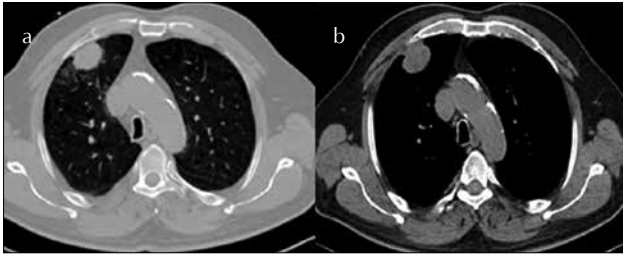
a, b. Computed tomography image: A 4-cm lesion in the right upper lobe
